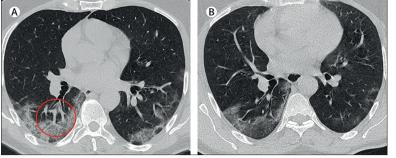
CT scan in the supine (A) and prone (B) positions in a male aged 53 years, with bilateral COVID-19 pneumonia, 7 days after the onset of the symptoms
